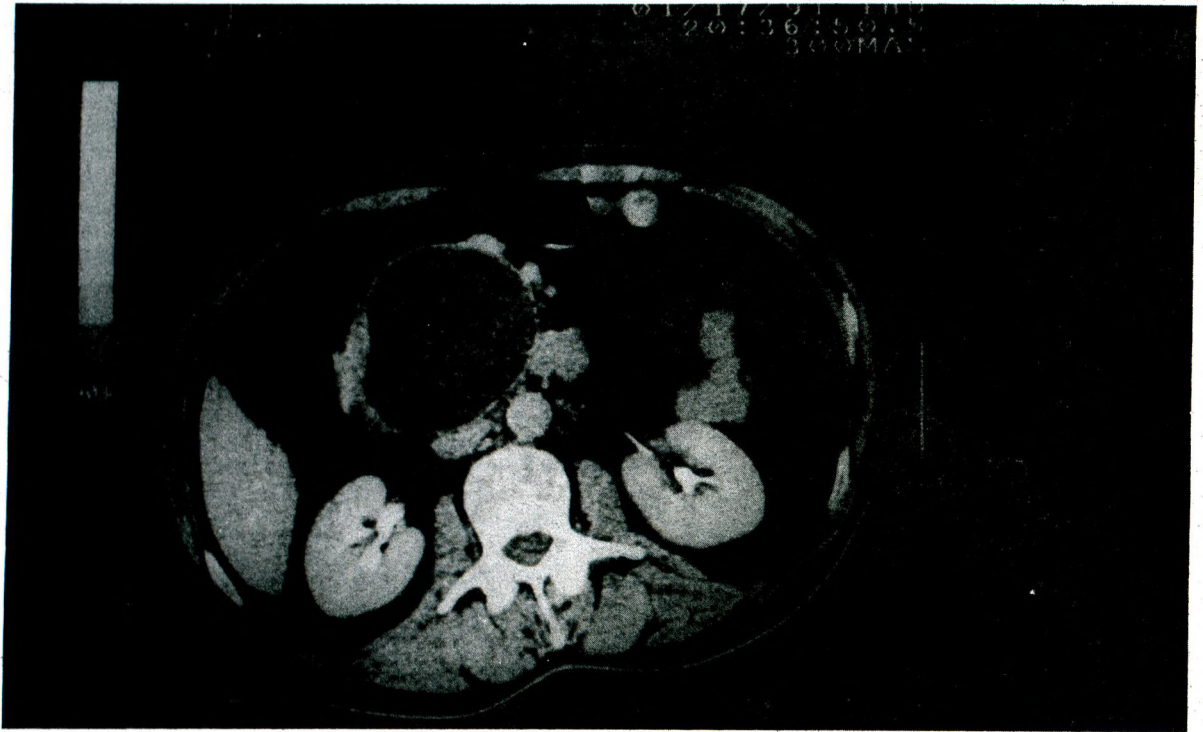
CT scan examination of pancreas after contrast enhancement shows a well defined, thin walled cystic mass in the head of pancreas.
